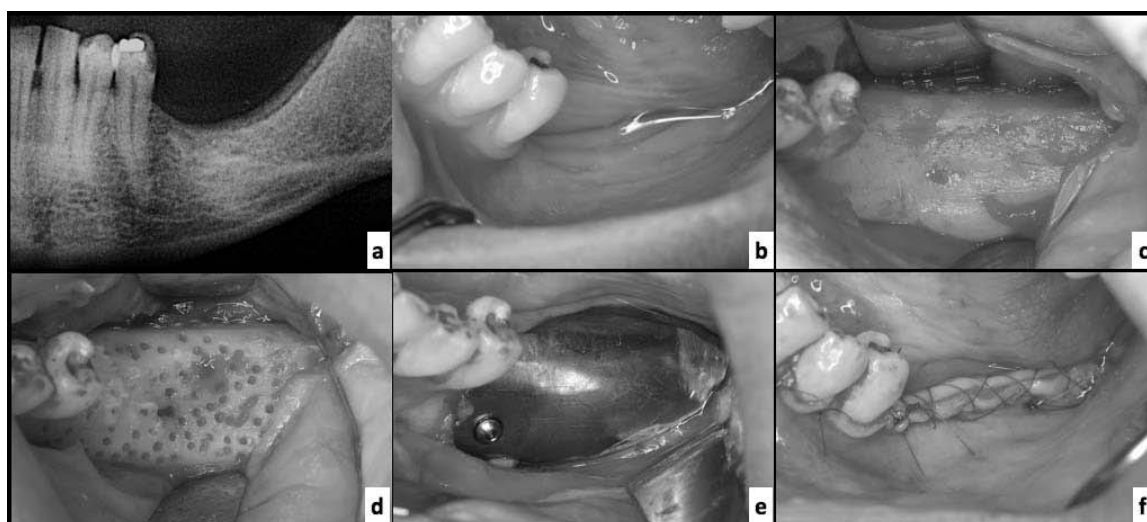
a)* panoramic X-ray of a distal mandibular area; *b)* intraoral view of the case; *c)* a full thickness flap was reflected; *d)* The cortical bone of the recipient site was then repeatedly punched until bleeding with a ball bur mounted on a contra-angle handpiece; *e)* the inner surface of the device was filled with the graft material and then immediately placed on the recipient site and fixed via screws; *f)* the flap is passivated and then sutured over the device.
